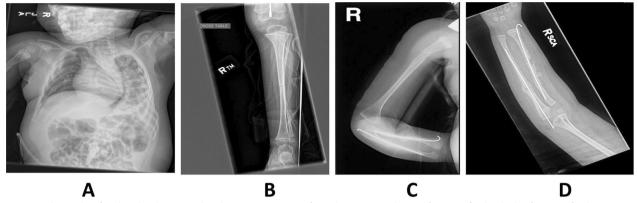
Radiographs of proband with SPARC-related osteogenesis imperfect showing A scoliosis, B fracture of right tibial, C fracture of right humerus, and D fractures of right radius and ulna
